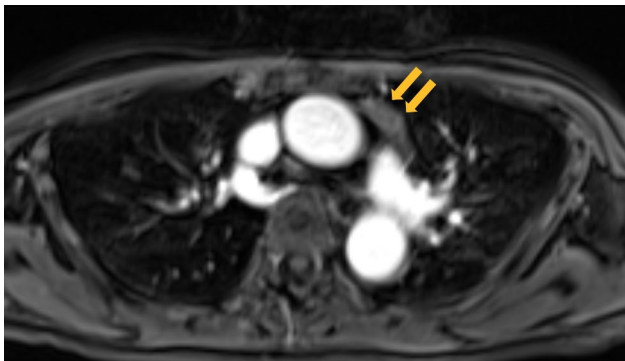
Chest contrast-enhanced MRI revealing a 17-mm tumor in the anterior mediastinum without fatty components (arrow). MRI, magnetic resonance imaging
